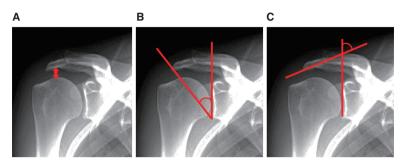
Standard anteroposterior radiographs of the AHD, CSA, and LAA
